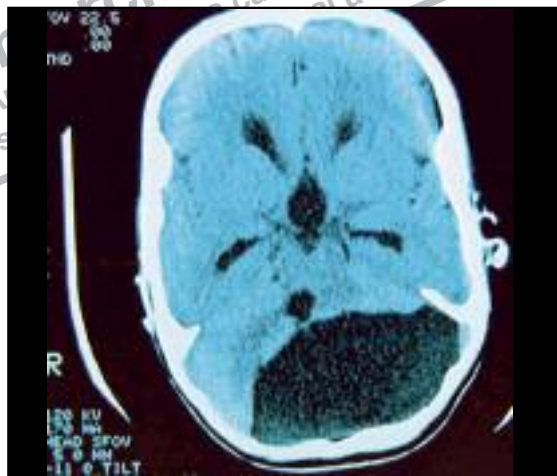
CT scan of brain.
